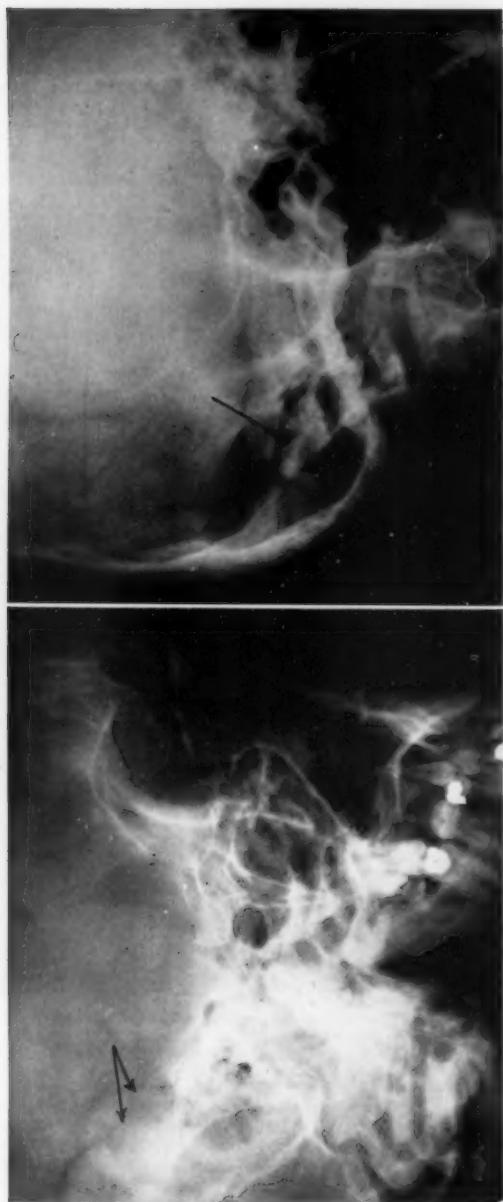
Case 3. Roentgenograms demonstrating the fracture in the left parietal bone and the fracture line in the left petrous.
